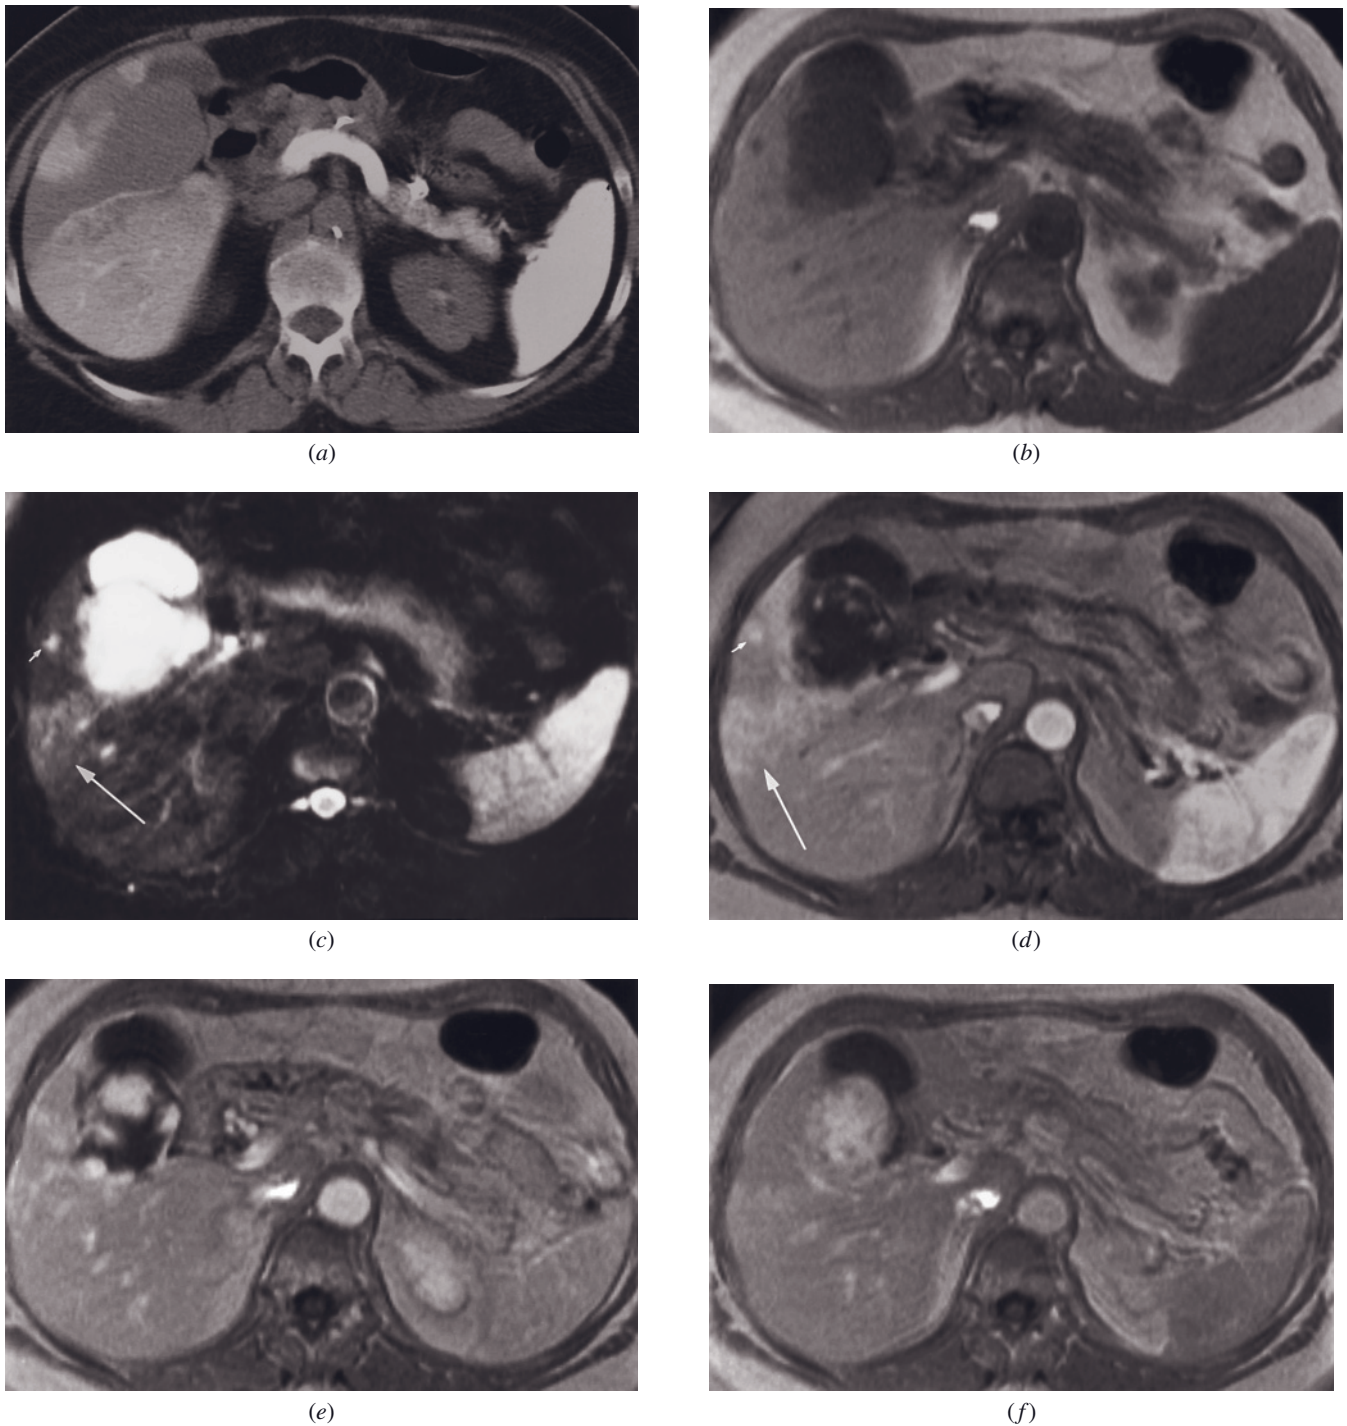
Hemangioma compressing portal vein. Spiral CTAP (*a*), SGE (*b*), T2-weighted fat-suppressed ETSE (*c*), and immediate (*d*), 90-s (*e*), and 10-min (*f*) postgadolinium SGE images. A 6-cm lesion is present in the anterior segment of the right lobe that causes distal wedge-shaped diminished portal venous perfusion on the CTAP image (*a*), findings that were considered consistent with a malignant tumor. The tumor is moderately low in signal intensity on T1-weighted image (*b*) and high in signal intensity on T2-weighted image (*c*) and has perilesional and peripheral nodular enhancement on early-phase image (*d*) that progressively fills in a centripetal fashion on late and delayed images (*e*, *f*). The perfusion defect observed on the CTAP image (*a*) is noted to be wedge-shaped and mildly hyperintense on T2-weighted image (long arrow, *c*) and enhances in a transient fashion greater than adjacent liver on the early-phase image (long arrow, *d*), findings consistent with portal vein compression. Additional note is made of a 6-mm hemangioma lateral to the large hemangioma (small arrow, *c*), which enhances intense and homogeneously on early-phase image (small arrow, *d*), compatible with a Type 1 pattern of enhancement.
